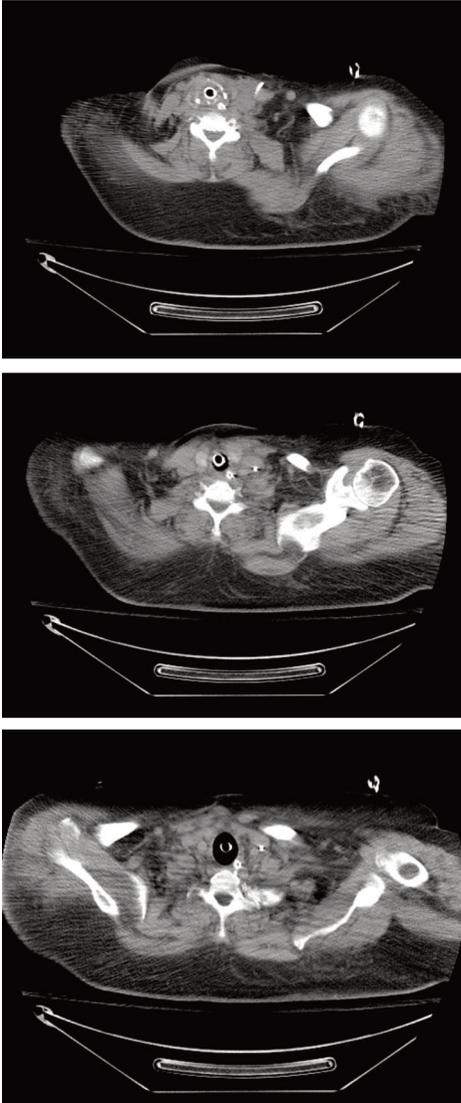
Neck CT scan at three different levels showing the endotracheal tube in the trachea and normal pretracheal and paratracheal space.
